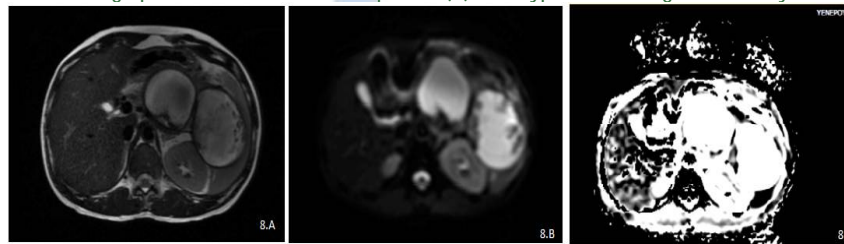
A case diagnosed as benign neoplasm of right adrenal gland showing mildly hyperintense mass lesion in the right adrenal on axial T2eSSFSE sequence (A) with areas of diffusion restriction on DWI sequence (B) and corresponding areas of ADC reversal (C) with ADC value of  $0.79 \times 10^{-3} \text{mm}^2/\text{s}$ . On HPE, the case was confirmed to be adrenal adenoma.
